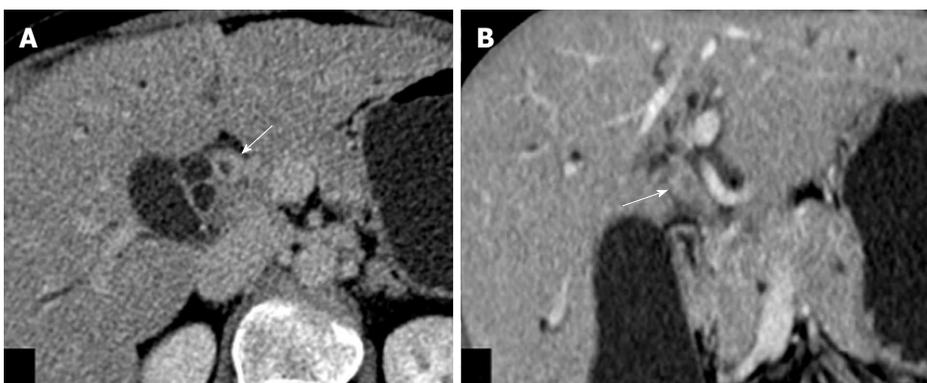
Axial (A) and coronal (B) images of venous phase of computed tomography scan of periductal infiltrating type of hilar cholangiocarcinoma showing wall thickening and enhancement of proximal common hepatic duct (arrow) causing luminal obstruction.
